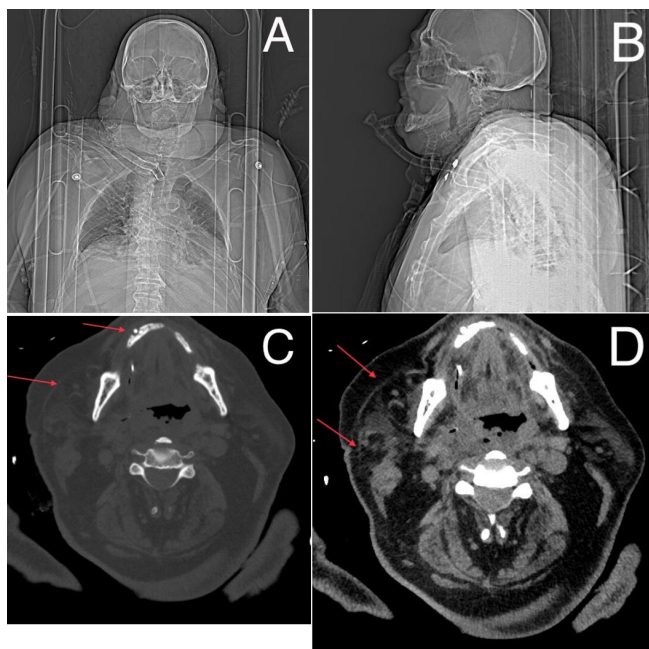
CT Chest/Neck/Mediastinum performed after the surgery: front (A), right side (B) and transverse plane (C-D) highlighting the presence of a chronic periapical inflammation at the dental element 4.3 and multiple gas bubbles in correspondence of the right submandibular plane.
